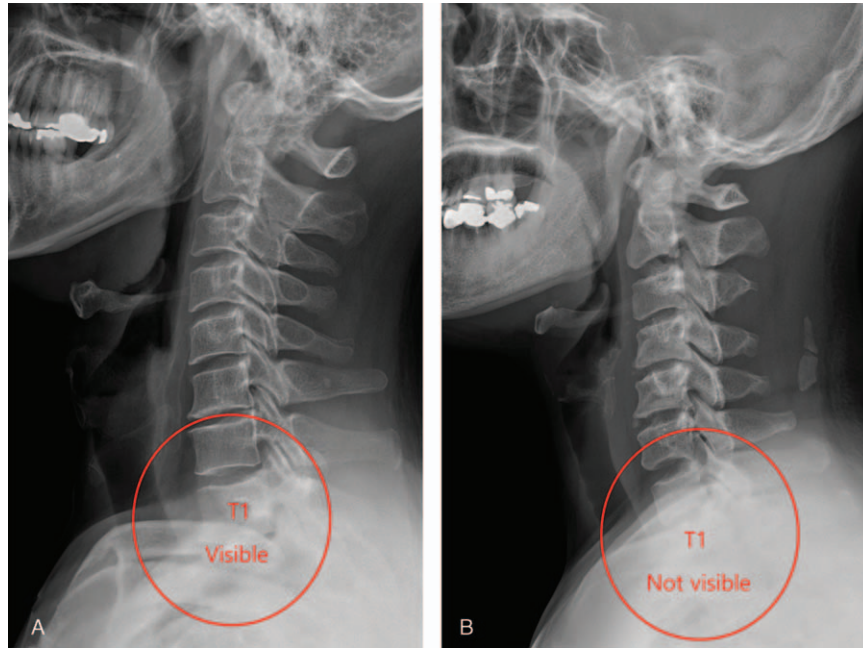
(A) T1 slope visible on the cervical spine lateral radiograph. (B) T1 slope not visible on the whole-spine lateral radiograph.
